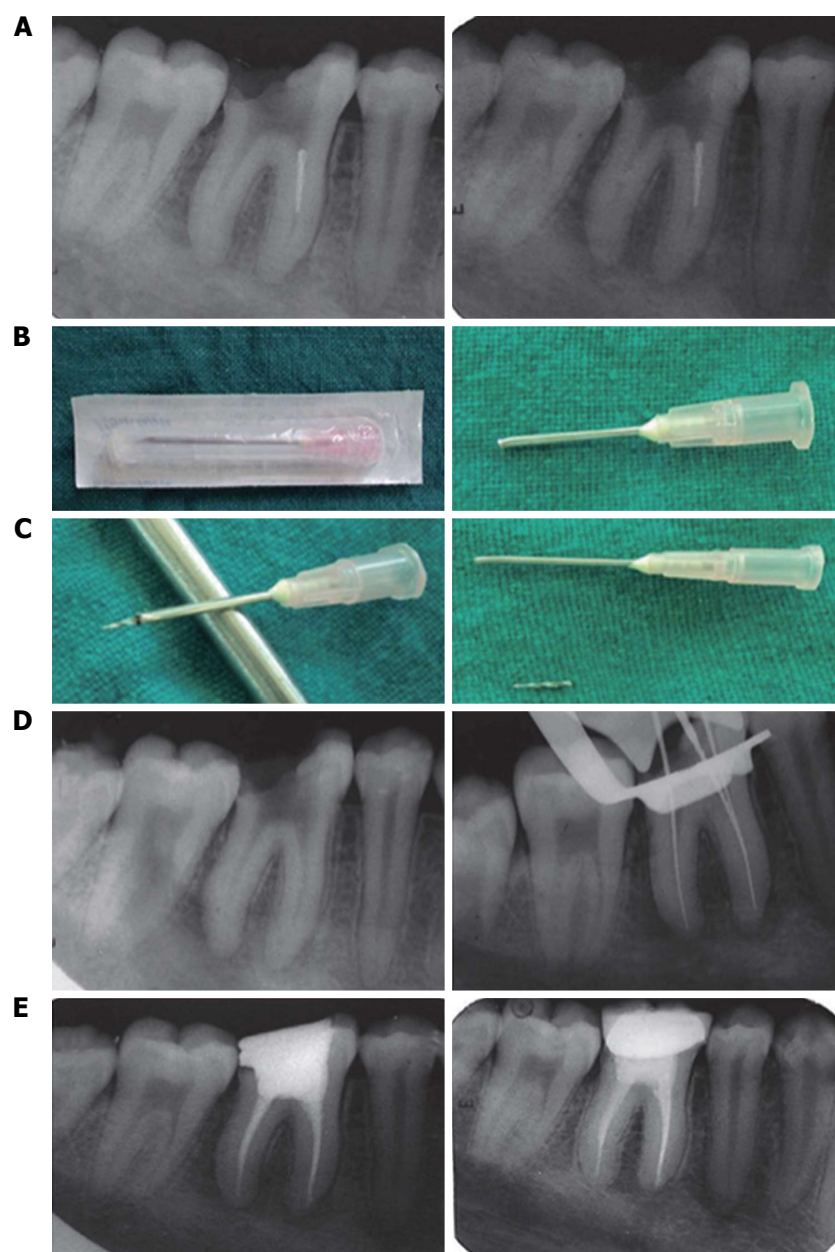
A modified 18-gauge needle and cyanoacrylate glue were used to retrieve a separated nickel-titanium instrument from the mesiolingual canal of a mandibular first molar. A: Radiograph showing separated instrument; Radiograph showing dentine surrounding the coronal end of the separated fragment removed with GG drill; B: An 18-gauge needle, modified by cutting with a carborundum disc from the tip to transform it into a microtube; C: Separated instrument fragment removed adhered to the microtube; D: Radiograph confirming instrument removal; Working length reconfirmed; Post-obturation radiograph; E: Two-year follow up radiograph.
